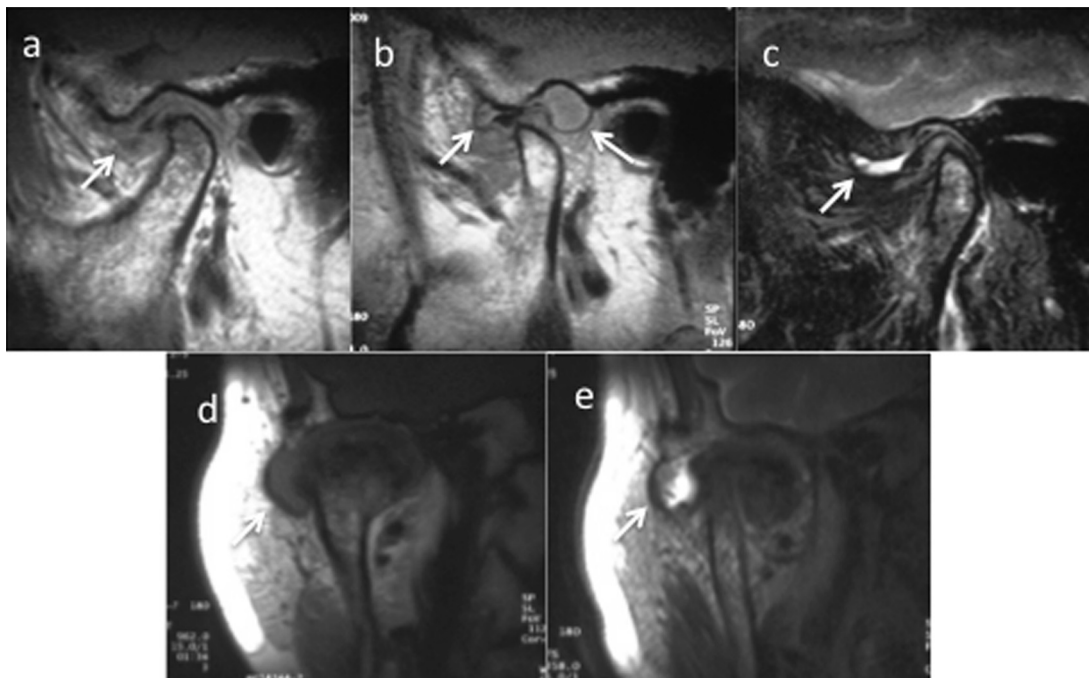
MRI of the right side TMJ. a: Sagittal PDWI (closed position). b: Sagittal PDWI (open position). c: Sagittal T2WI (closed position). d: Frontal PDWI (closed position). e: Frontal T2WI (closed position). A medium signal intensity area thought to be due to a mass lesion was observed in PDWI and expansion of the upper joint space was suspected (a, b, d, arrows indicate). Joint effusion with hypertrophy of the synovium with low signal intensity spots in the upper joint space was found on T2WI (c, e, arrows indicate).
